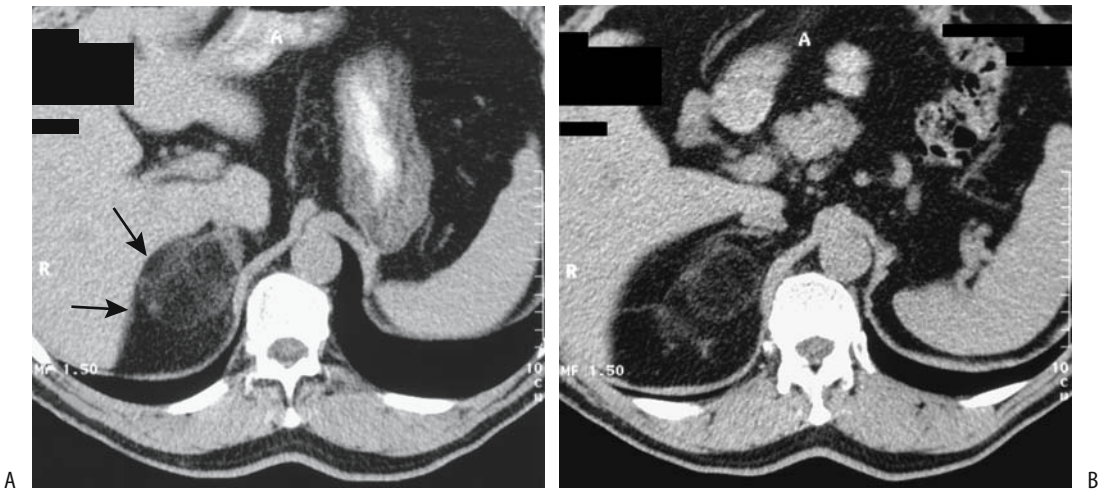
Adrenal myelolipoma. A,B: Computed tomography shows a fat-containing structure (arrows) that has replaced the right adrenal gland. It is surrounded by extensive perirenal fat. (Courtesy of Algidas Basevicius, M.D., Kaunas Medical University, Kaunas, Lithuania.)
